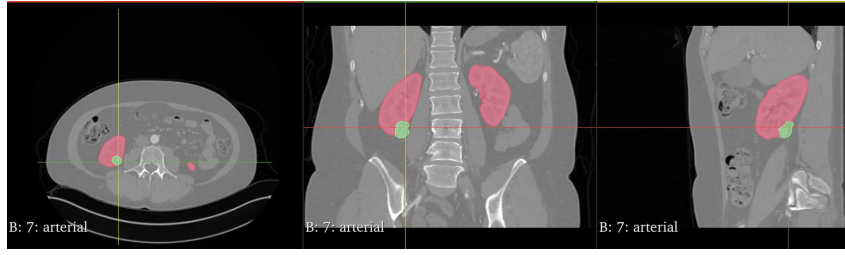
Visualization of the "arterial" contrast-enhanced CT scan and segmentation for patient KiTS0000 in the axial, coronal, and sagittal planes, via 3D Slicer.
